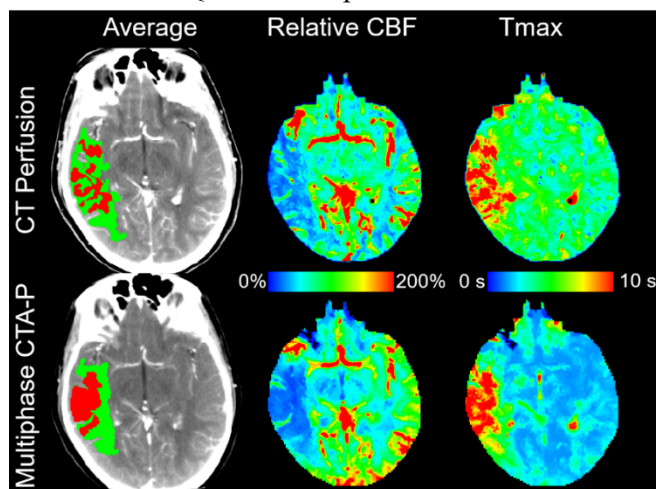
Perfusion maps derived from CT perfusion (top row) and mCTA-P (bottom row). Infarct (red) and penumbra (green) overlaid on dynamic CT average maps (left column). Relative CBF (middle column) and Tmax maps (right column) show similar ischemic regions.
